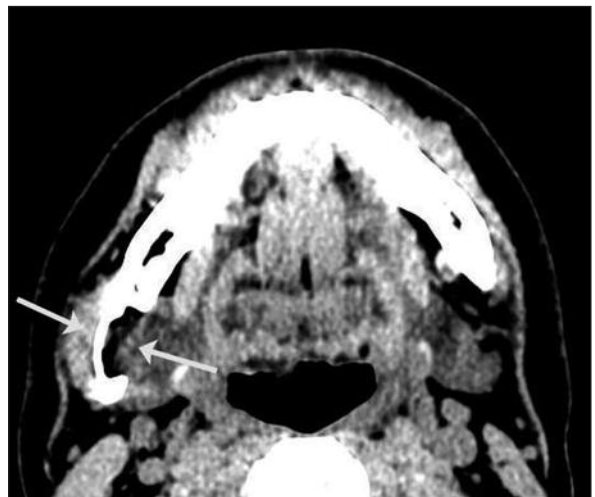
Axial CT scans, using soft tissue window, showing soft tissue mass (arrowed) on the lingual cortex of the mandible. Mesiodistal location of the defect; the long black line shows Mylohyoid muscle. Dental CT showed submandibular gland and fat tissue of low attenuation in the cavity of the mandible.
